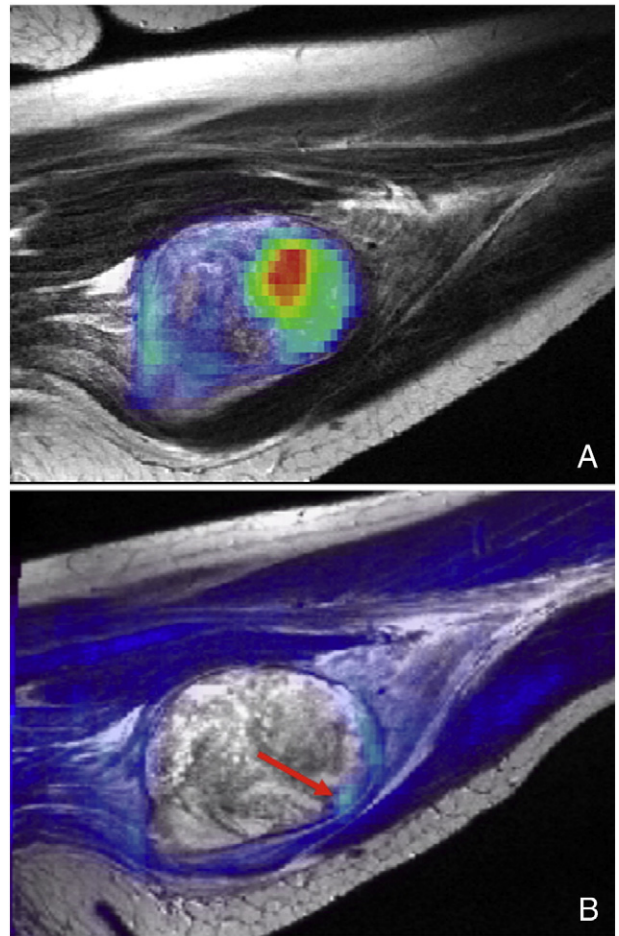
A. Pre-radiotherapy fused PET and T2-W MRI. B. Post-radiotherapy fused PET and T2-WMRI. On T2-weighted MR, the initial tumor and edema margins extend beyond the region of high ^{18}F -FDG uptake. Pathology of the excised tumor found malignant cells corresponding only to the regions of abnormally high ^{18}F -FDG uptake. On post-radiotherapy scans, residual high ^{18}F -FDG uptake (red arrow) was demonstrated by MRS and confirmed by pathology, to represent post-radiation inflammation rather than residual tumor.
